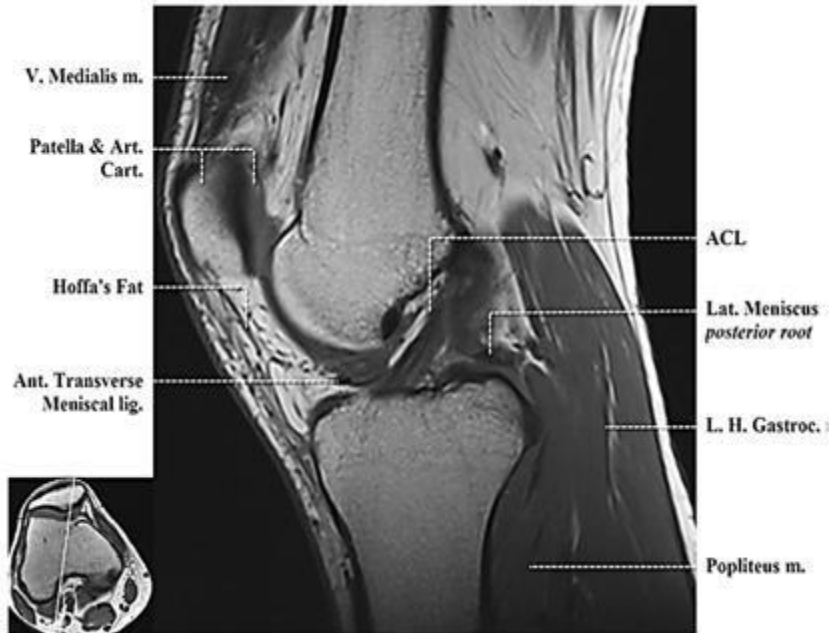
Sagittal T1-weighted MRI image showing intercondylar notch.
